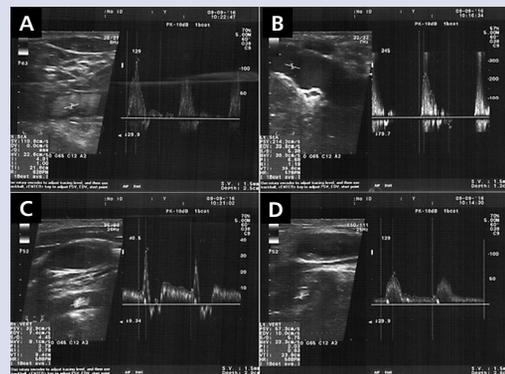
Duplex-Doppler examination presents proper waveform spectrum in: RSA (A), LSA (B), LVA (D), RVA (C) with the ultrasonographic signs for steal syndrome, without clinical symptoms
